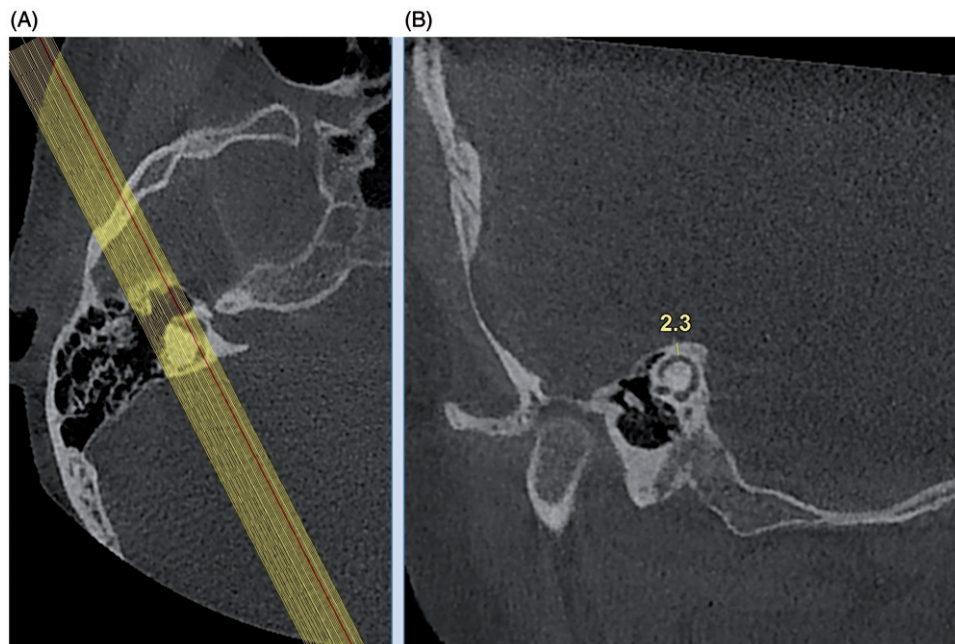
Cone beam computed tomography images. (A) Pöschl plane. Angle of reformation showed on axial CBCT image. (B) Normal features are seen as a whole ring on axial reformatted image.
